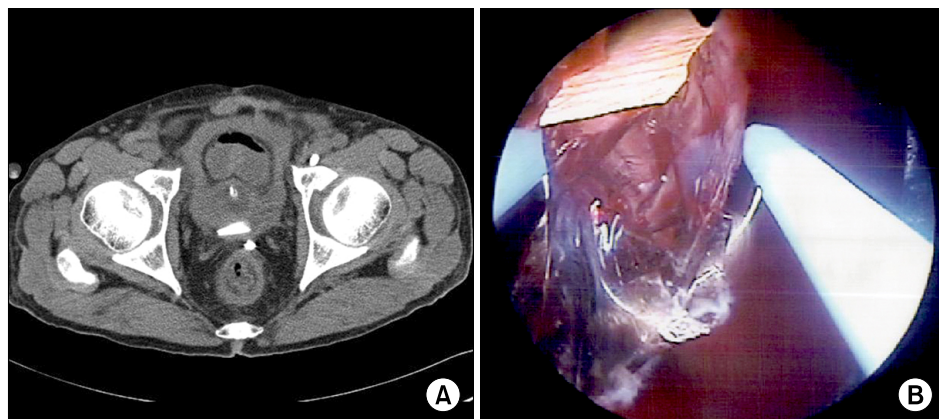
(A) Follow-up CT shows a newly detected hyperdense lesion inside the bladder. (B) Cystoscopy shows an intravesical 2x0.7 cm glass particle.
